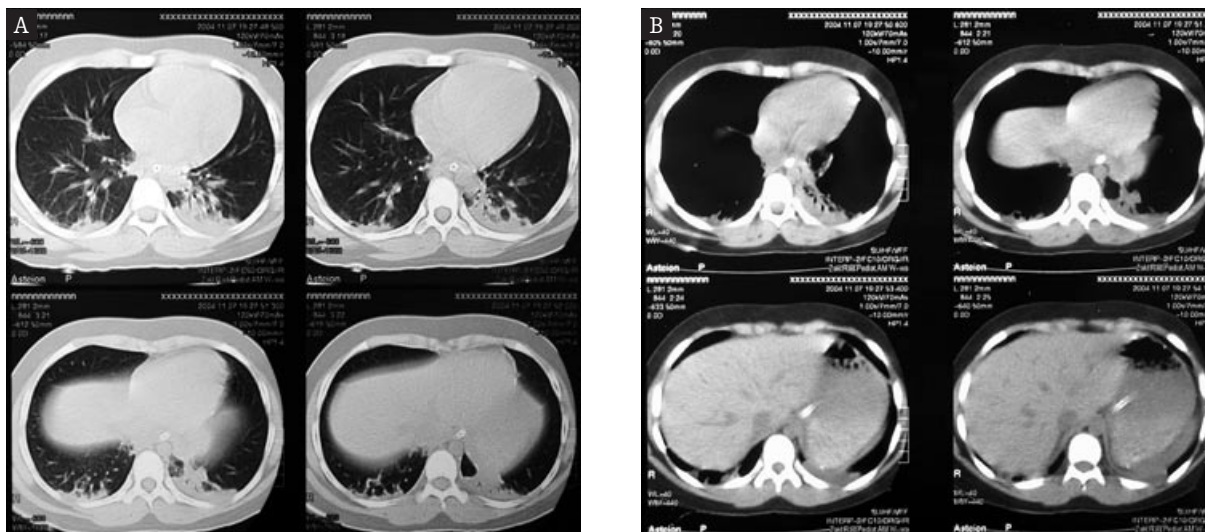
Chest CT: A) contusion of the lower parts of both lungs, B) free fluid between spleen and diaphragm.
